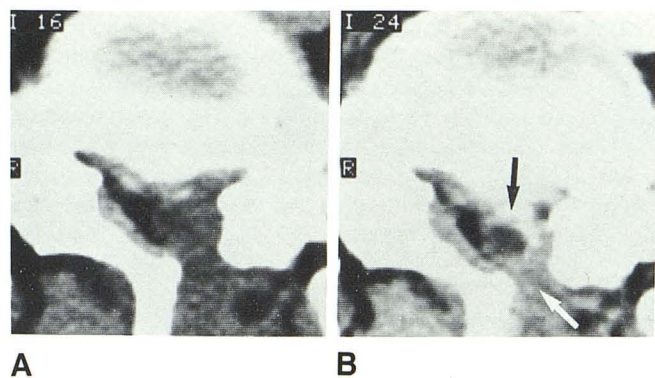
Extradural scar extending around dural sac. A, Unenhanced CT scan. Sac has been pulled over to left and seems to merge with scar filling left lateral part of canal. Two densities anteriorly in canal are unusually dense vessels of epidural plexus. B, After enhancement. Scar increases markedly in density (black arrow) and extends to surround about half of thecal sac, clearly outlining its border. Scar (white arrow) along left canal wall and laminectomy site enhances less intensely than anterior of scar and sac, probably due to presence of interspersed epidural fat within posterior scar.
